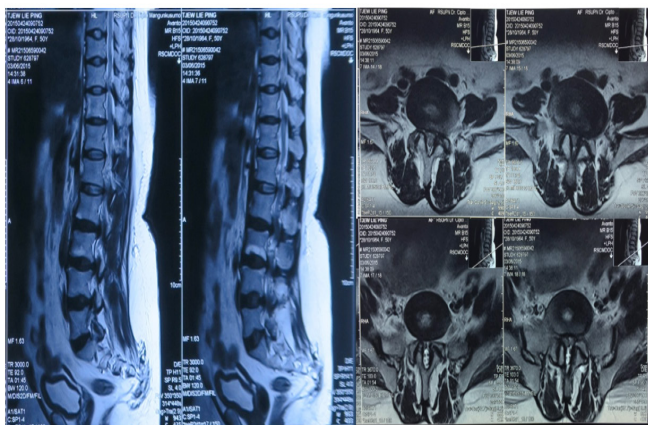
Pre-Operative MRI Examination
